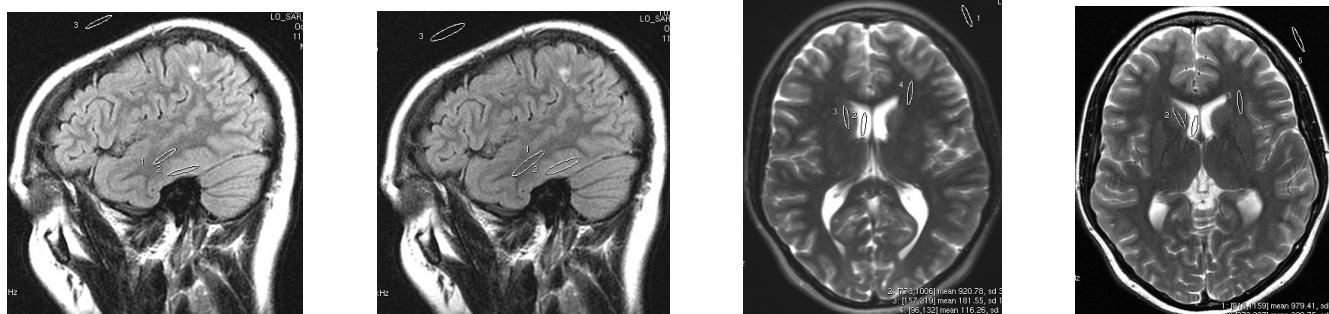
(A) low-SAR 3D FLAIR section with 5 slices averaged to match (B) 5mm thick 2D Clinical FLAIR section. Also shown is (C) 3D axial reformat with 5 mm average from 1 mm low-SAR 3D T₂ acquisition and (D) 5 mm thick 2D Clinical T₂ image. ROIs in GM, WM and CSF are used to compute SNR and CNR (Table 1).
